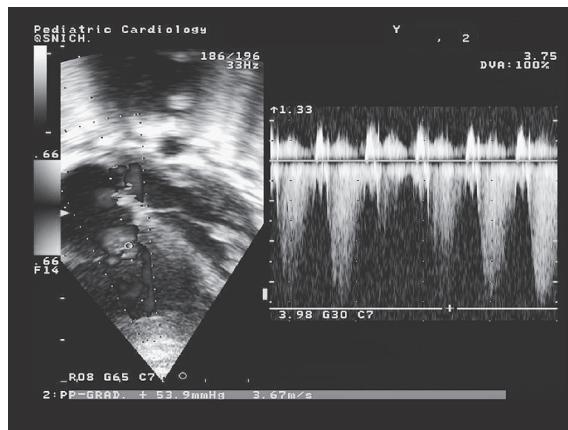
Echocardiogram revealed moderate tricuspid regurgitation with estimated systolic pulmonary pressure of 60 mmHg
